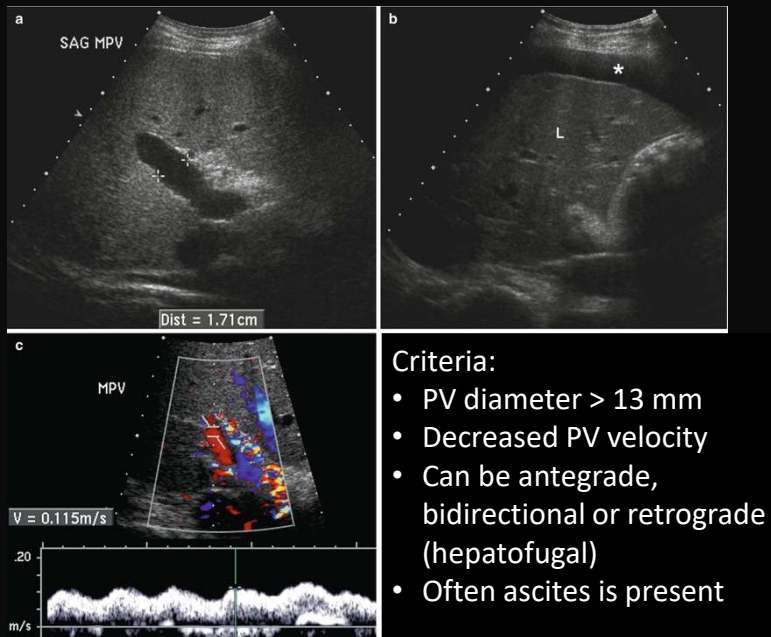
5. Benson, C. B. Ultrasound of the Hepatoportal Circulation
